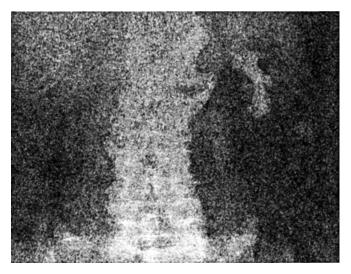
Plain film shows a staghorn calculus on the left side
